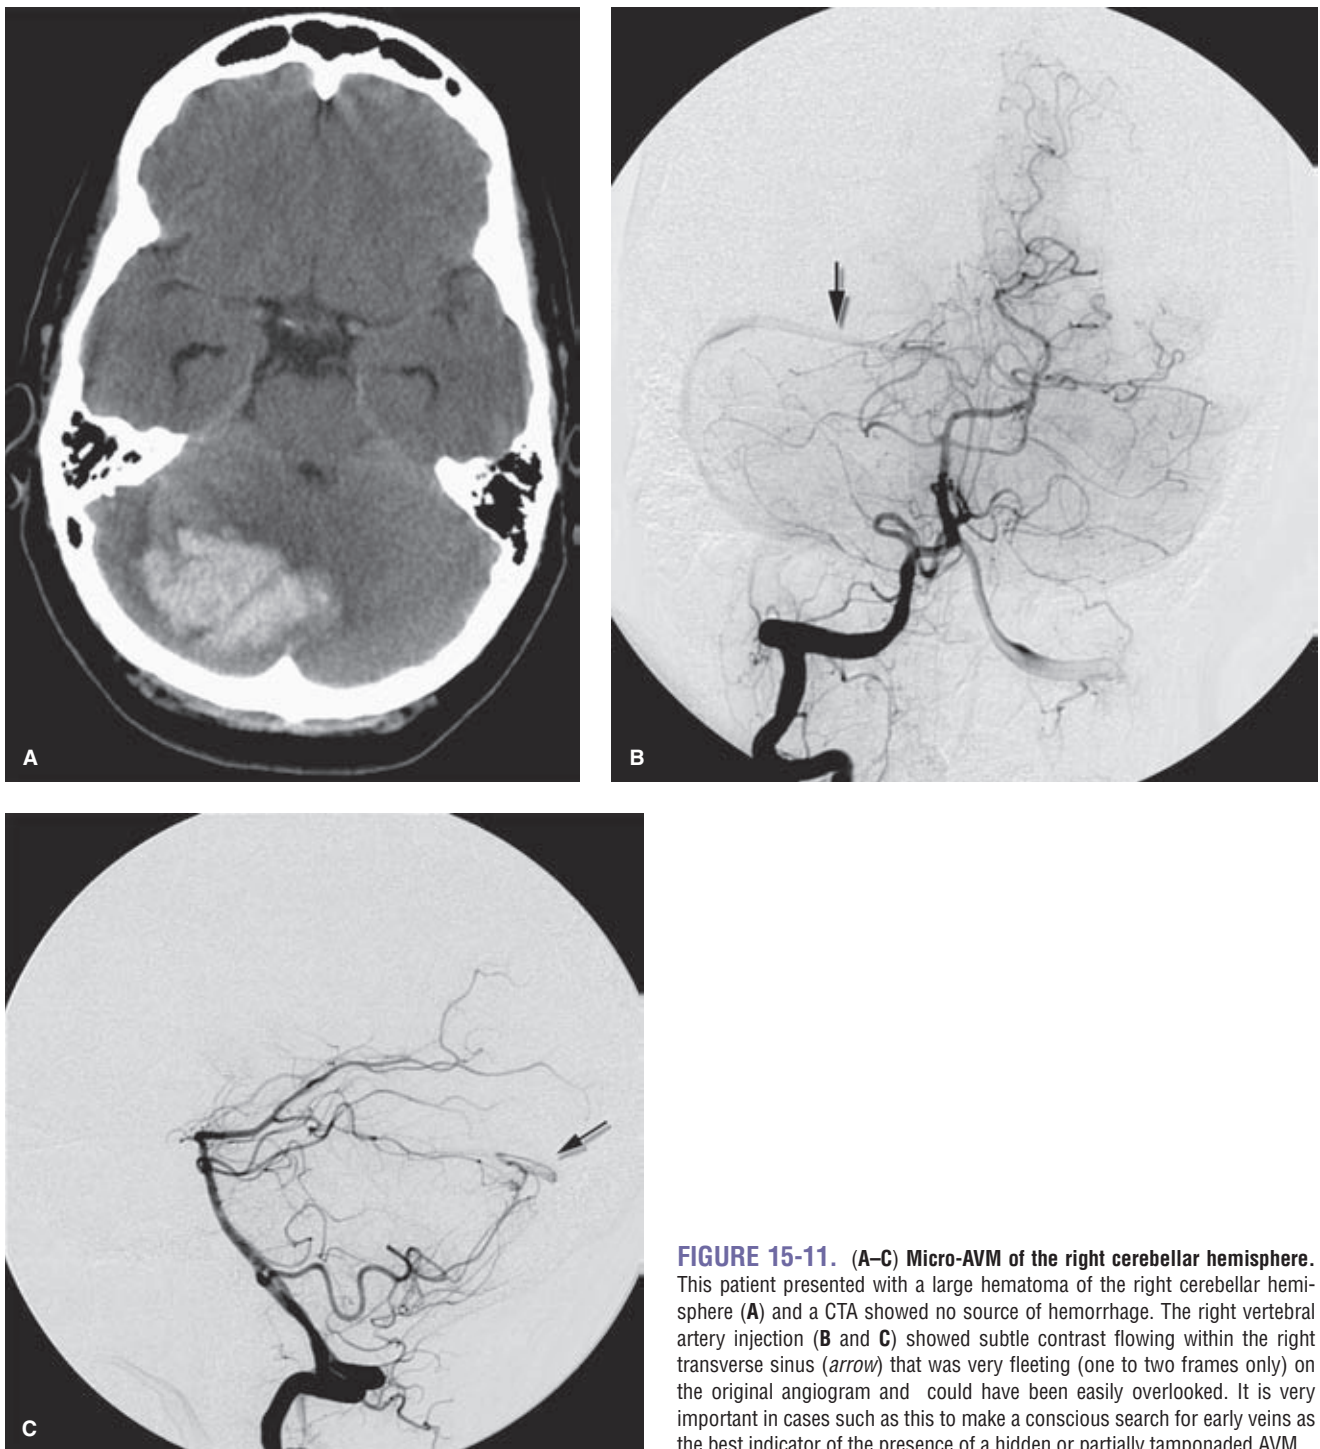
(A–C) Micro-AVM of the right cerebellar hemisphere. This patient presented with a large hematoma of the right cerebellar hemisphere (A) and a CTA showed no source of hemorrhage. The right vertebral artery injection (B and C) showed subtle contrast flowing within the right transverse sinus (arrow) that was very fleeting (one to two frames only) on the original angiogram and could have been easily overlooked. It is very important in cases such as this to make a conscious search for early veins as the best indicator of the presence of a hidden or partially tamponaded AVM.
